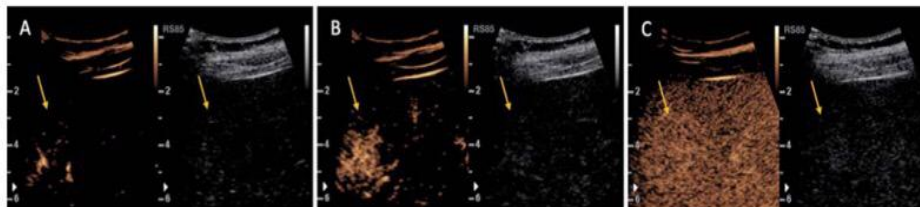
Same patient as in Figure 1. Split-screen contrast-enhanced sonograms (left panels) and B-mode US (right panels) from intercostal views demonstrate a focal nodular hyperplasia (arrows). A and B: arterial phase shows the centrifugal filling of the lesion (10-14 seconds after administration of contrast agent). C: Sustained enhancement of the lesion was showed in the portal venous and late phase, the lesion appears slightly hyperechoic or isoechoic relative to the surrounding liver parenchyma.
